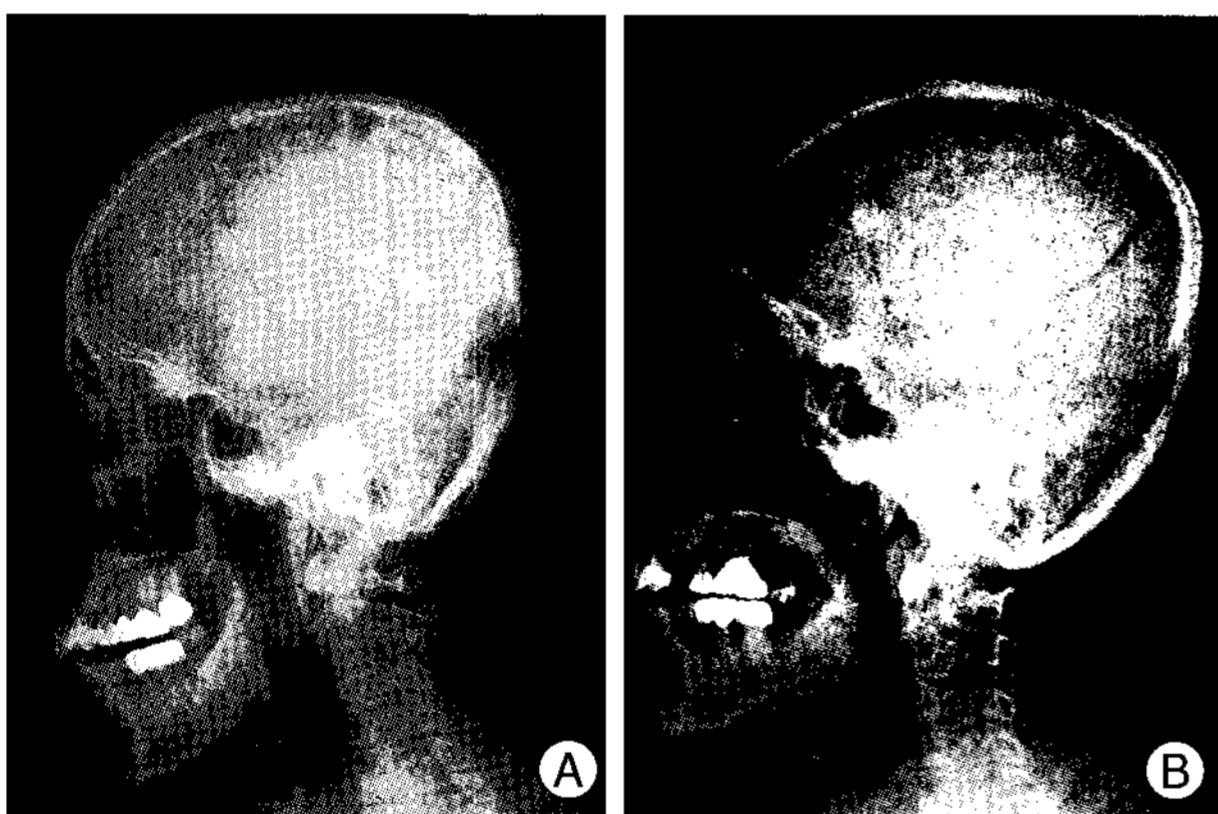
Simple skull X-rays taken 20 days (A) and 66 days after first craniotomy (B) showing the progression of an osteolytic lesion in upper portion of bone flap and in the adjacent surrounding bone.
